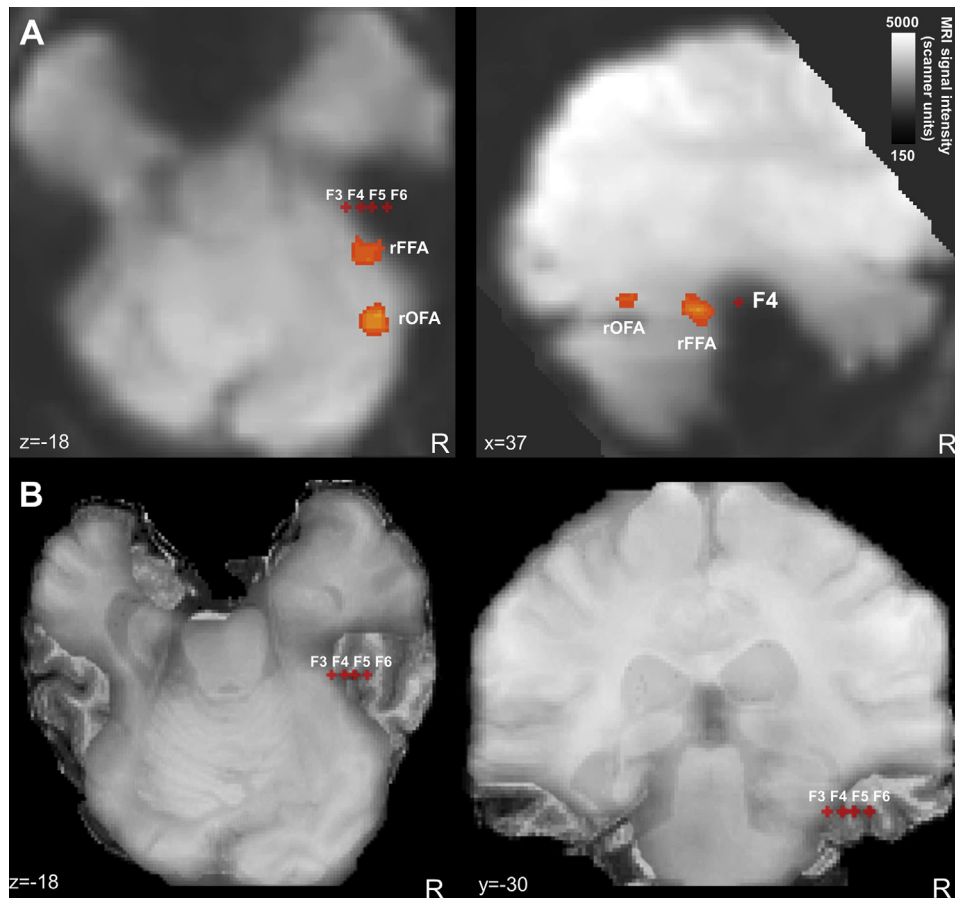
The critical stimulation sites are located in a MRI signal drop-out. A. Face-selective areas (rOFA and rFFA) and intracerebral contacts F3, F4, F5 and F6 are shown on raw functional slices (axial and sagittal slices). The MRI signal intensity shows a strong signal drop-out in the antero-inferior temporal cortex (in black), where these contacts are located. The right OFA and FFA are spared by this drop-out. B. Superimposition of raw functional and anatomical images (axial and coronal slices), showing that the signal drop-out specifically involved the anterior FG and the inferior temporal gyrus.
